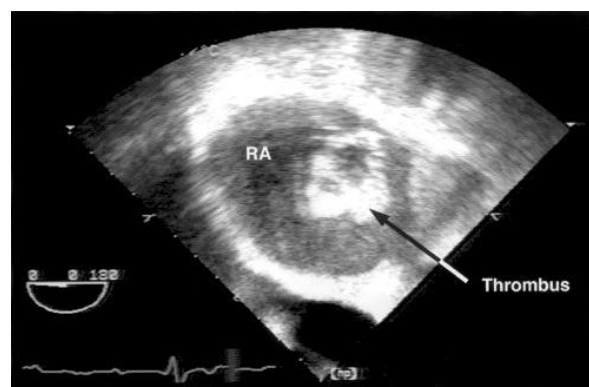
Echocardiographic image of a large thrombus.
